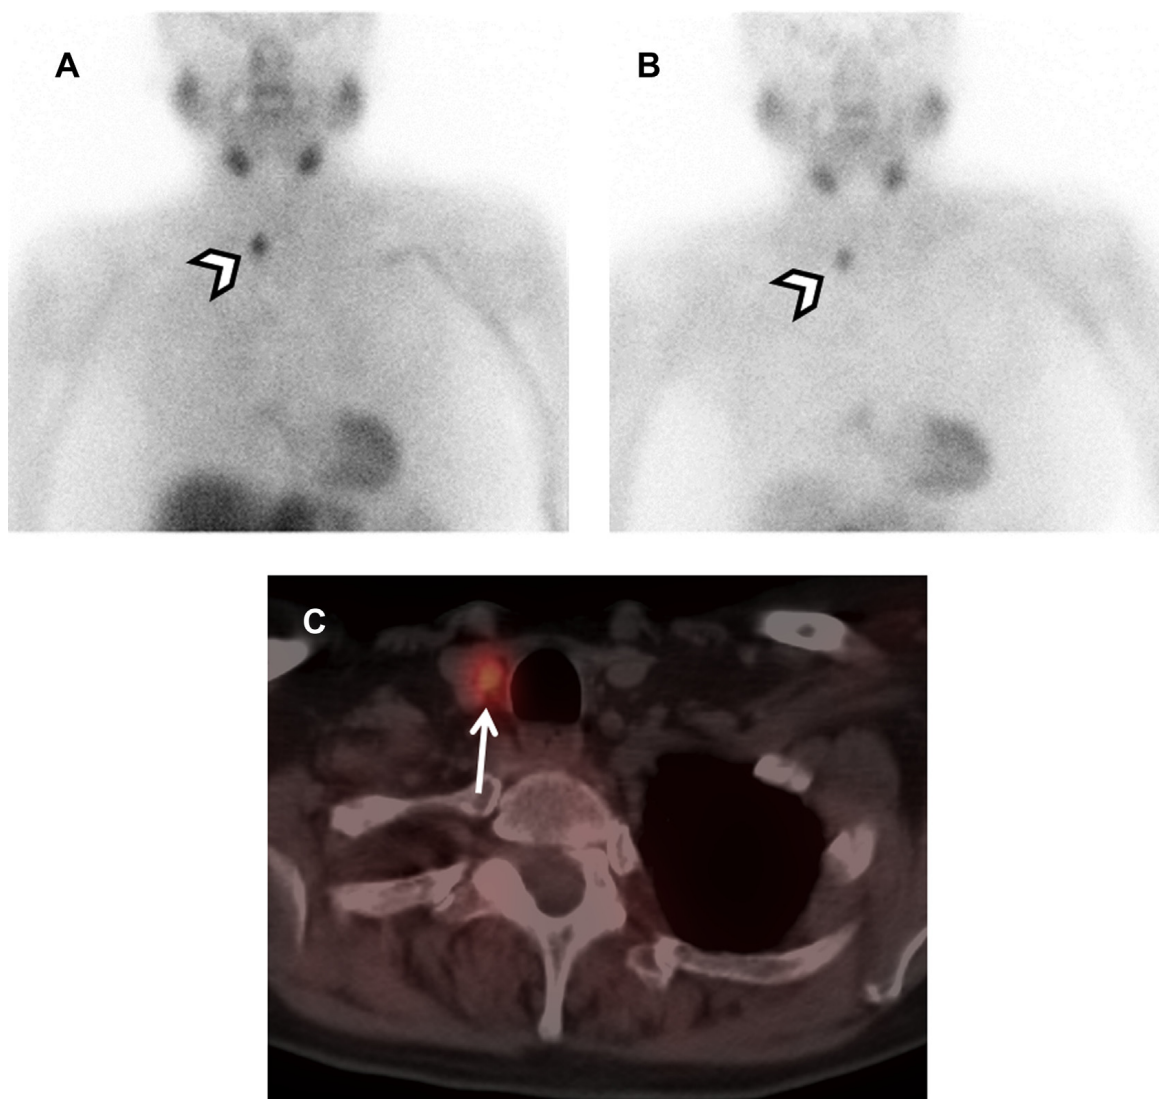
Parathyroid adenoma on sestamibi scan. (A) Immediate and (B) delayed anterior images of Tc-99m sestamibi in a 73-year-old woman with prior thyroidectomy. A focus of increased uptake (arrowheads) in the right inferior neck is very clearly visualized given lack of uptake in the thyroid bed. (C) Fused axial SPECT/CT images localize the area of increased uptake to a small soft tissue nodule, consistent with parathyroid adenoma (arrow).
